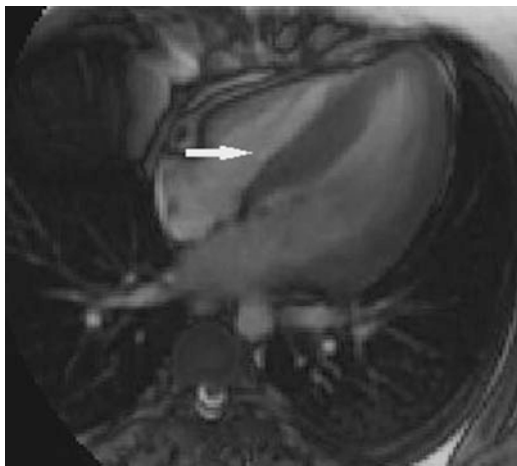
A 15-year-old boy with hypertrophic cardiomyopathy presented with tachycardia. Cardiac MRI showed hypertrophy of the left ventricle with increased thickness of the septum (*arrow*). There is systolic anterior motion of the anterior mitral leaflet with associated mitral regurgitation and left ventricular outflow tract obstruction (Courtesy of Dr. Grace Guo)
